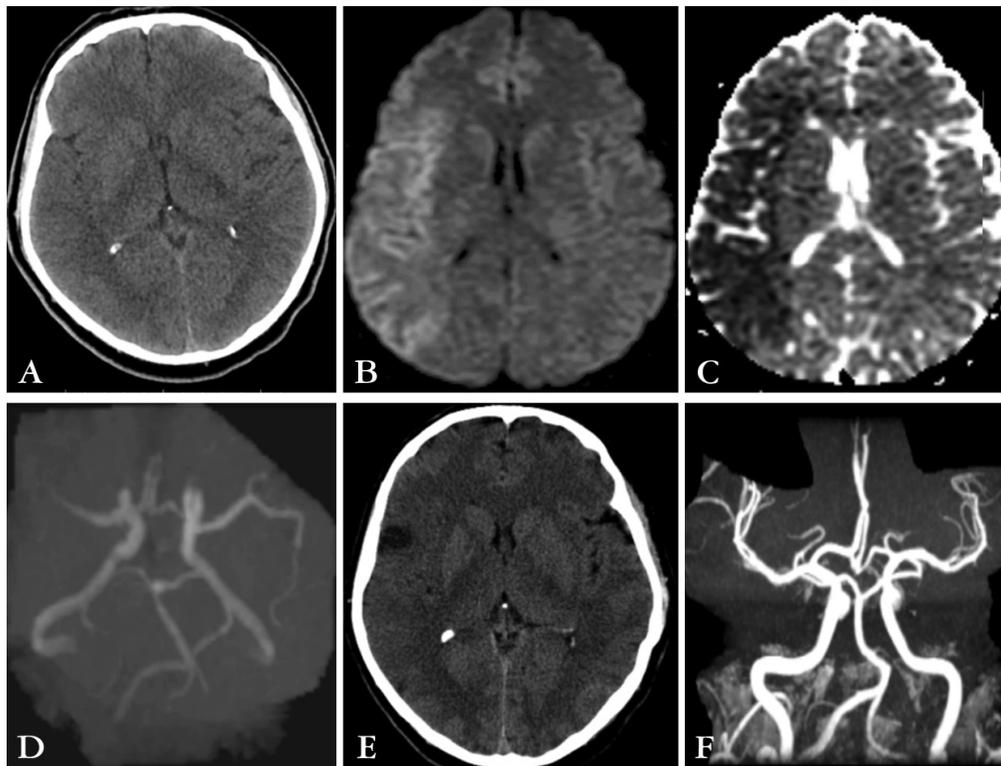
A 55-year-old male. On neurologic examination, the patient was somnolent, left homonymous hemianopsia, left 2/5 hemiparesis. National Institutes of Health Stroke Scale: 15, symptom/needle: 80 min. A) Normal cranial computerized tomography scan at the time of admission to the emergency department. B, C) Diffusion restriction in the right middle cerebral artery area on diffusion magnetic resonance imaging. D) Right middle cerebral artery occlusion on magnetic resonance angiography. E) A small infarct in the right parietal area on cranial computerized tomography 24 hours after treatment. F) Magnetic resonance angiogram shows recanalization of the artery (modified Rankin Scale: 0).
